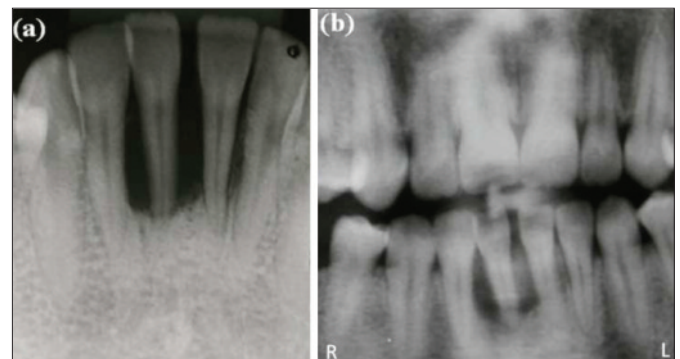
(a,b): (a) Periapical radiograph showing severe horizontal alveolar bone loss in the mandibular central incisor region with loss of integrity of the duralamina and widening of the periodontal ligament. (b) Section of a panoramic radiograph showing severe horizontal alveolar bone loss in the mandibular central incisor area.
